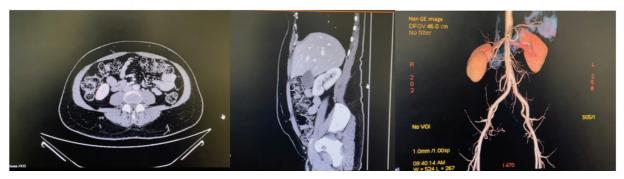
Preoperative computed tomography angiogram to locate the perforator for deep inferior epigastric perforator flap.
